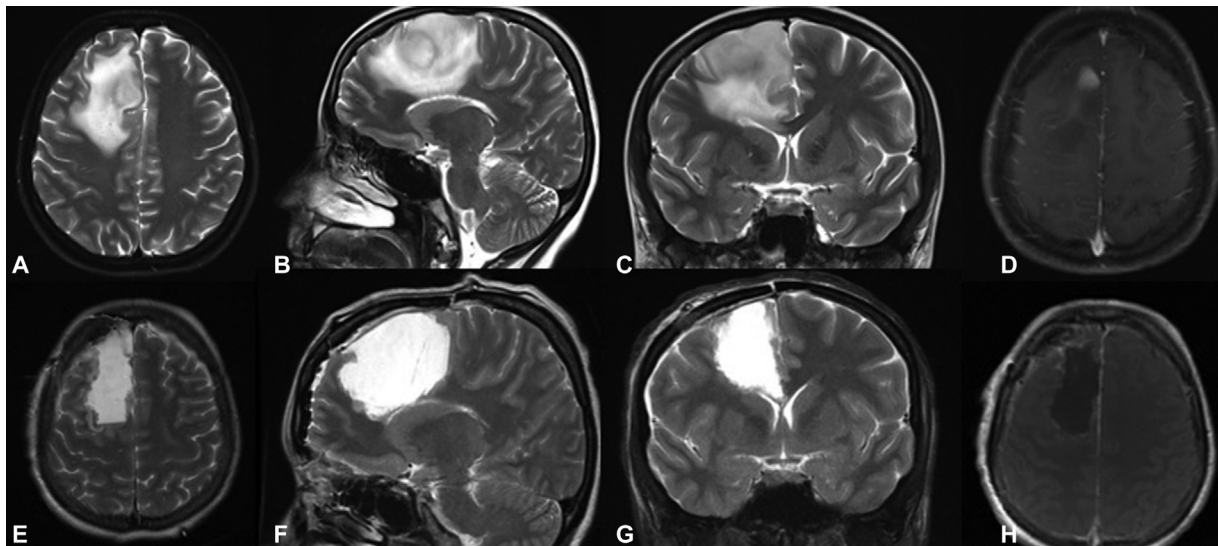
Preoperative and immediate postoperative images of case 2. (A–D) are the T2 axial, T2 sagittal, T2 coronal, and T1 postcontrast axial images showing T2 heterogeneously hyperintense lesion involving right middle and posterior aspect of superior frontal gyrus, extending up to premotor region; lesion is hypo in T1 and showed a small nodular enhancement anteriorly and few areas of patchy enhancement posteriorly. (E–G) are the T2 axial, sagittal, and coronal immediate postoperative MRI images and H is the postcontrast T1 axial image showing complete resection of the tumor.
